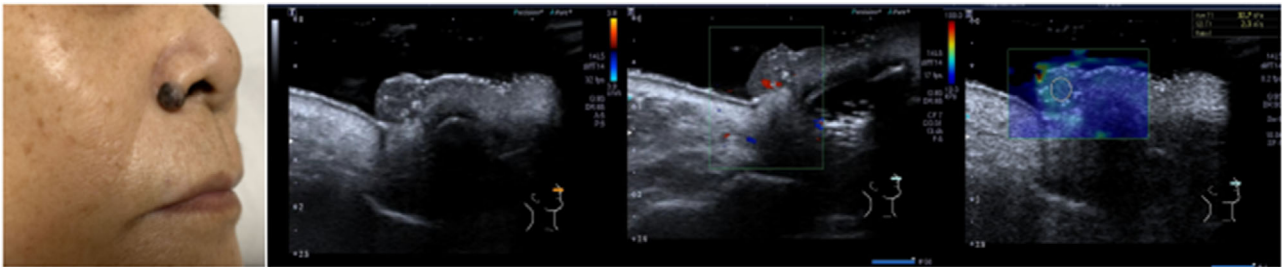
2D, Doppler, and SWE images of BCC
